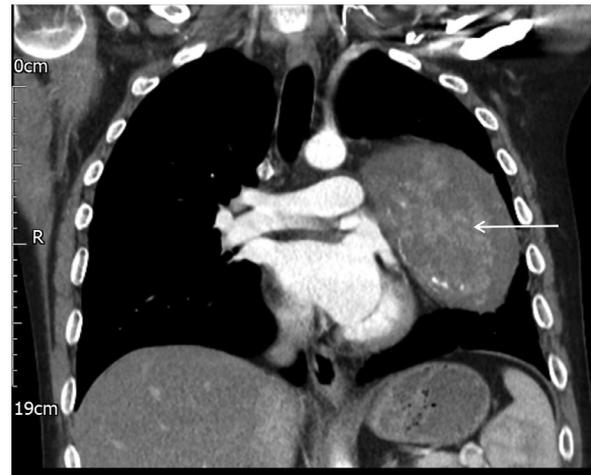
Enhanced computed tomography prior to excisional biopsy demonstrates residual mass with internal calcifications (white arrow)
